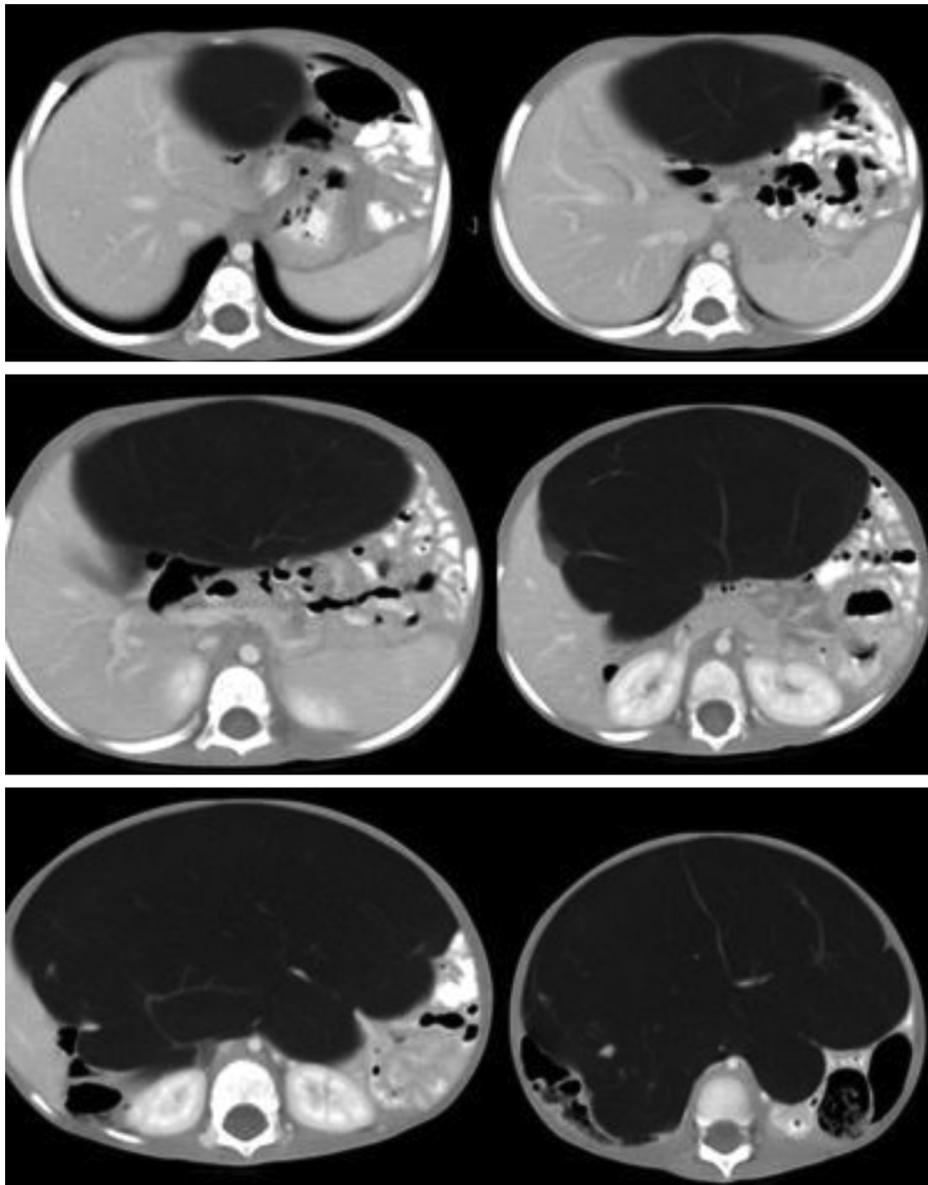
CT of abdomen revealed 20 × 10 × 10 cm a well encapsulated fatty mass in the mesentery resulting in crowding of the mesenteric structures. The picture was most consistent with a lipoma.
